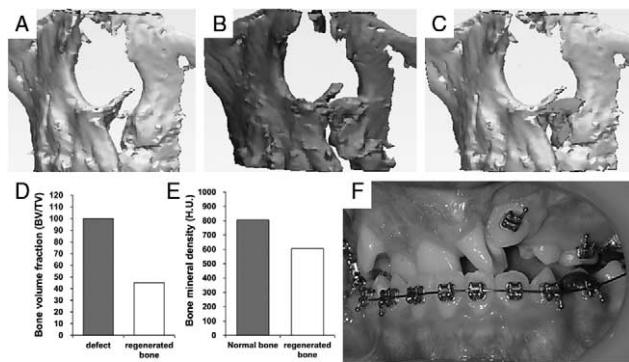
Postoperative results. (A) Defect model, (B) 3D reconstructed computed tomography data 6 months after transplantation, (C) a merged image of the preoperative scaffold (purple) and the newly regenerated bone (green), (D) bone volume fraction, (E) bone mineral density, and (F) closing the oronasal fistula.
